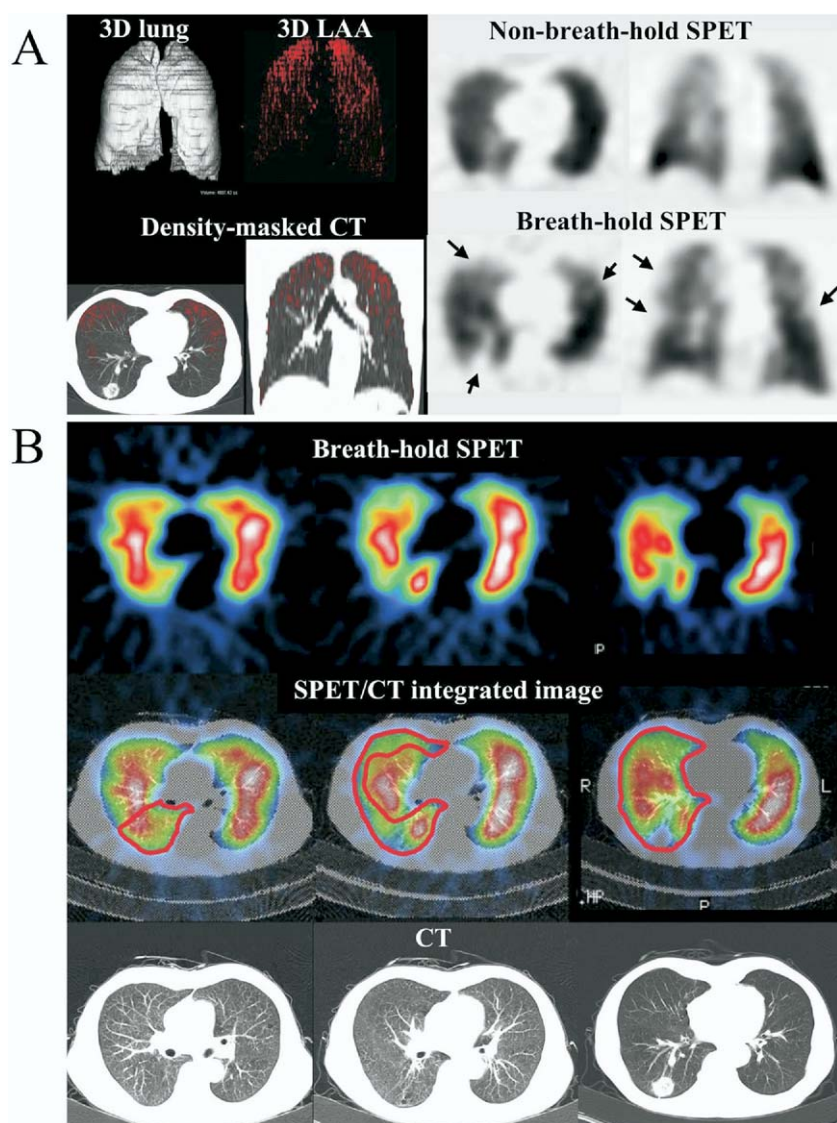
A, Three-dimensional (3D) lung volume and low-attenuation area (LAA) images (top left), density-masked computed tomographic (CT) image of the lung plane (bottom left), and breath-hold and standard non-breath-hold perfusion single-photon emission CT (SPET) images (right) in a 77-year-old man with adenocarcinoma in the right lower lobe and diffuse emphysema. The red areas on 3D LAA and density-masked CT images represent the distribution of emphysematous areas with CT attenuation values of less than -910 HU. The 3D LAA and density-masked CT images (left) clearly show that this patient has a moderate extent of focal emphysema, with an emphysema index of 18.2%, and a forced expiratory volume in 1 second (FEV_1) of 2.64 L. Although heterogeneous perfusion defects were seen on breath-hold and non-breath-hold images at the same transaxial lung plane as in the CT image and in the coronal dorsal lung plane, some defects were more distinct on the breath-hold images (right, arrows). Breath-hold SPET images showed extended perfusion defects at normal lung areas without LAAs. B, Image set of transaxial breath-hold SPET, SPET/CT integrated, and CT images. For regions of interest (ROI) placement (red solid lines) to predict postoperative FEV_1 after right middle and lower lobectomy, individual lung lobe borders could be outlined comprehensively by referring to the integrated images, although the borders were unclear on SPET images alone. In this patient the predicted FEV_1 of 1.96 L provided on the basis of integrated images was correlated better with the postoperative actual FEV_1 of 1.98 L than the predicted value of 1.63 L determined by means of lung segment counting.
